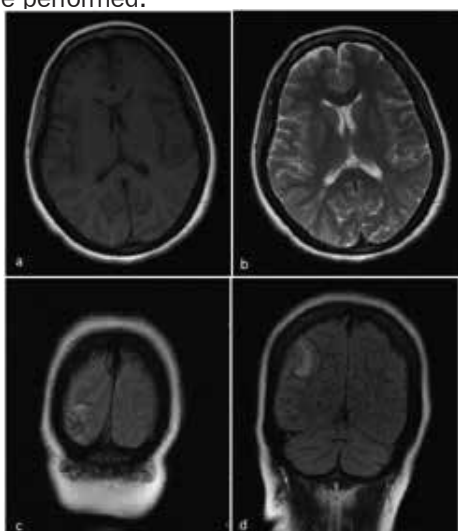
a-T1WI, b-T2WI, c-d FLAIR images.
